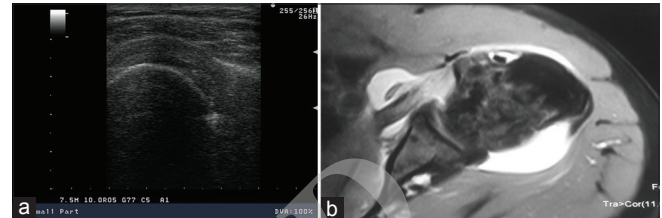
(a) Short-axis ultrasound image showing bulky heterogeneous subscapularis tendon suggestive of tendinitis. (b) Axial PD-weighted image showing hyperintense signal involving subscapularis tendon with associated distended subscapularis bursa representing tendinitis
